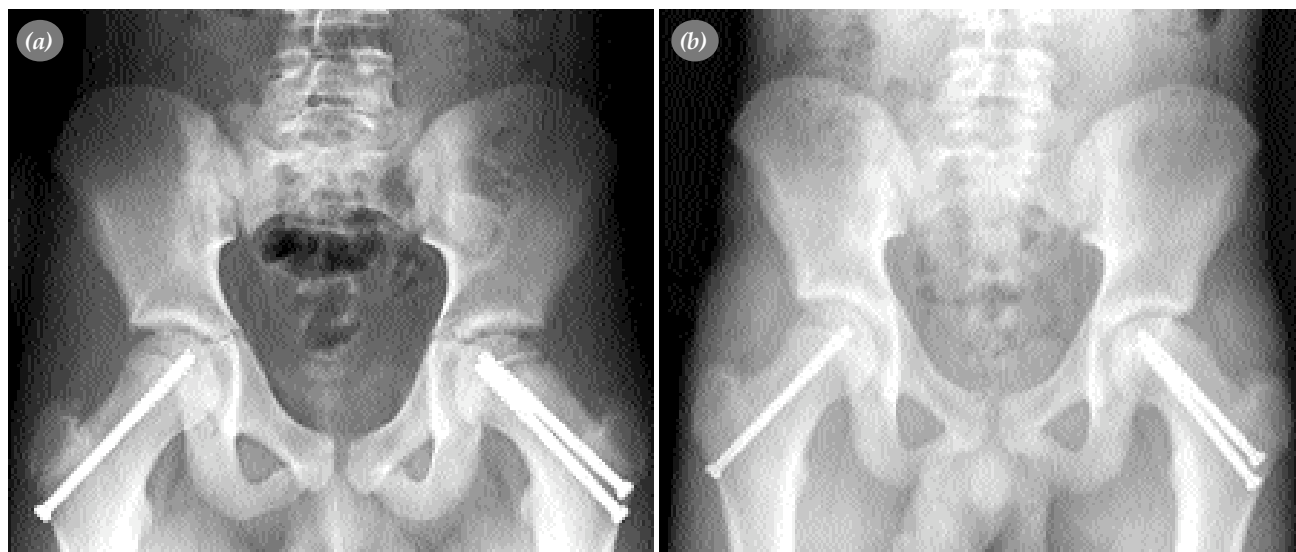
In situ fixation of SCFE (early post-operative radiography) (b) Post operative 3.month radiography of the same patient with early findings AVN
